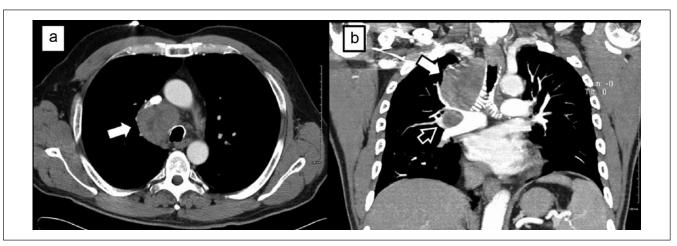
(a) A transverse cut in CT scan of the chest showing enlarged right paratracheal lymph node (white arrow) and (b) a coronal cut in CAT scan of the chest showing enlarged right paratracheal lymph node (white arrow) and enlarged right hilar lymph node (black arrow).
